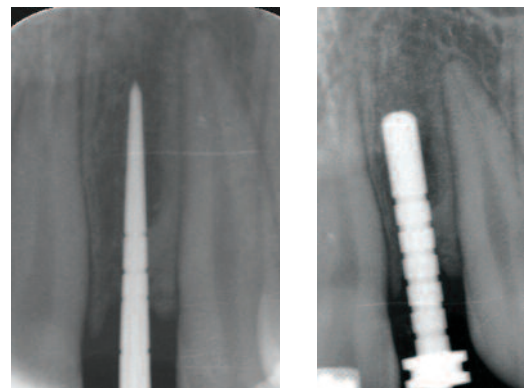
Radiographic verification of osteotome position.
